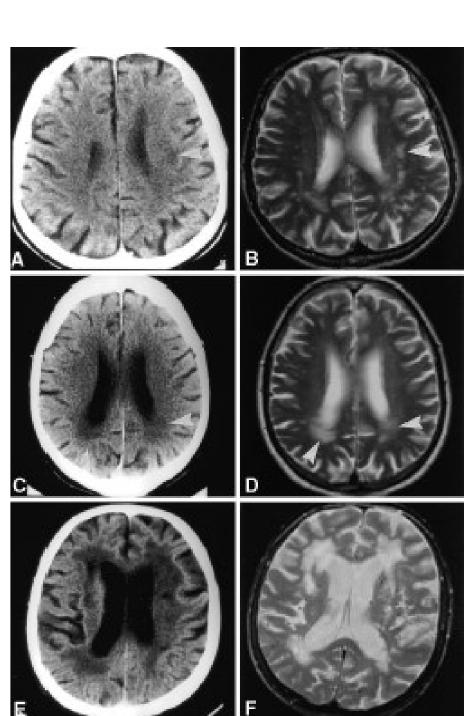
A through F, Examples of the rating scores 1, 2, and 3 from CT and MRI scans. Each pair of images (CT/MRI) refers to the same patient. The lesions are chosen from matching slices. Note that the slice angulation differs between CT and MRI (T2-weighted MRI images are shown). For a rating score of 1, a single lesion is clearly seen on CT (A) (see arrow); on MRI (B), additional lesions are rated as 2; rating score 2 is exemplified in C and D (see arrows); rating score 3 is shown in E and F.
